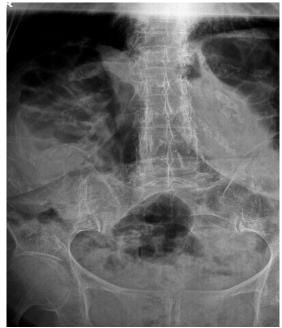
X-ray of the lumbar spine.
